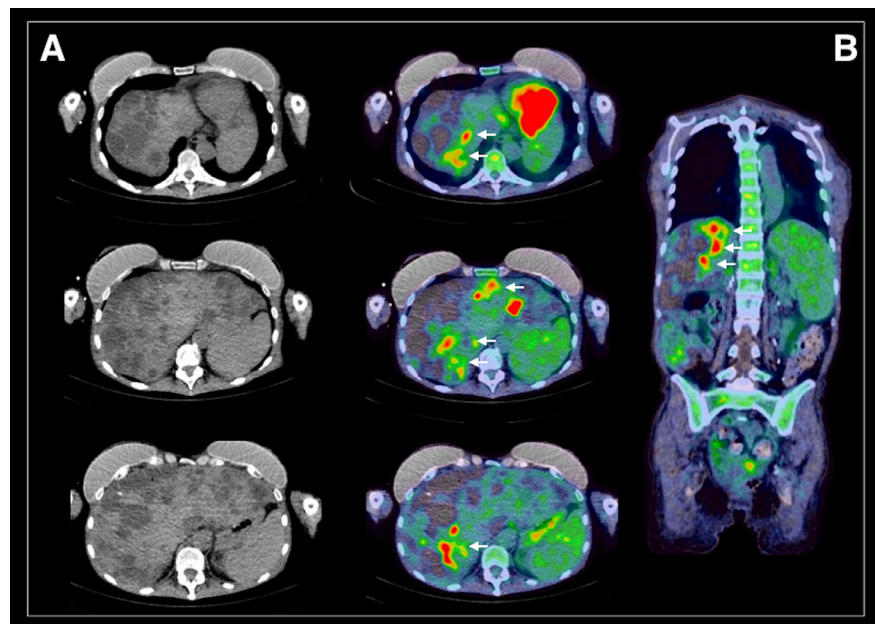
18F-FDG positron emission tomography/computed tomography in (A) transverse and (B) coronal planes demonstrated multiple pathological foci (white arrows) in both liver lobes, surrounding diffusely spread intra-parenchymal liver cysts.
